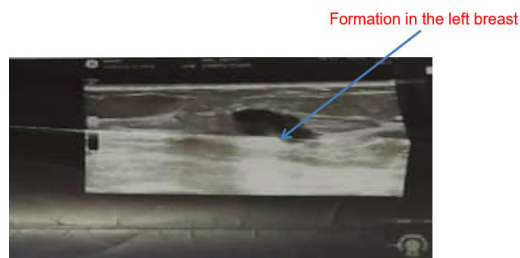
Ultrasound image of patient 4.
